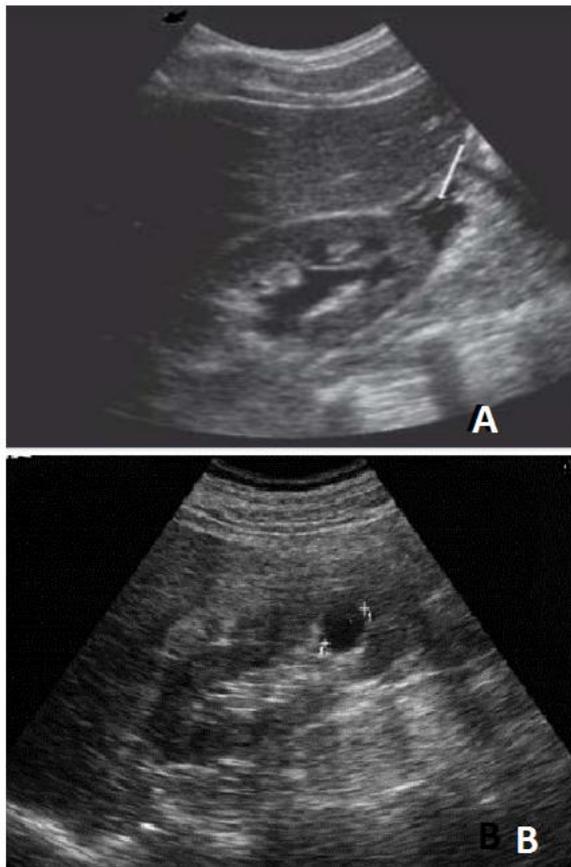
Shows ultrasound findings in two months old infant with pks: ( a: increased echogenicity of the left kidney parenchyma, b: parapelvic cyst in middle pole of right kidney )
